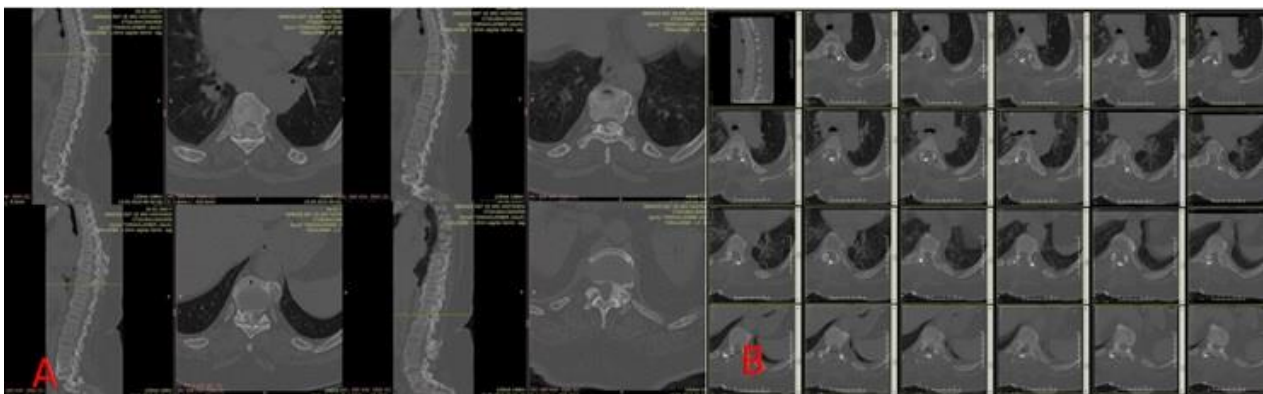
Images of computerized tomography (CT) sagittal and axial sections in a patient with eight levels of thoracic spinal stenosis who underwent laminoplasty A: Pre-operative B: Post-operative
